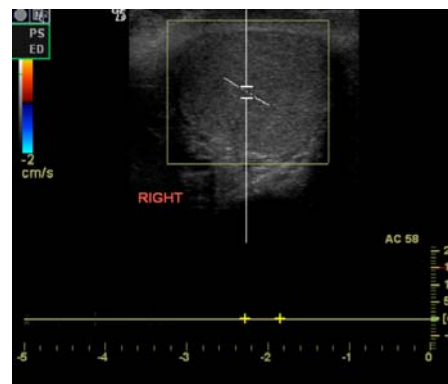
Color Doppler US scan revealing absence of blood flow to the right testicle.
